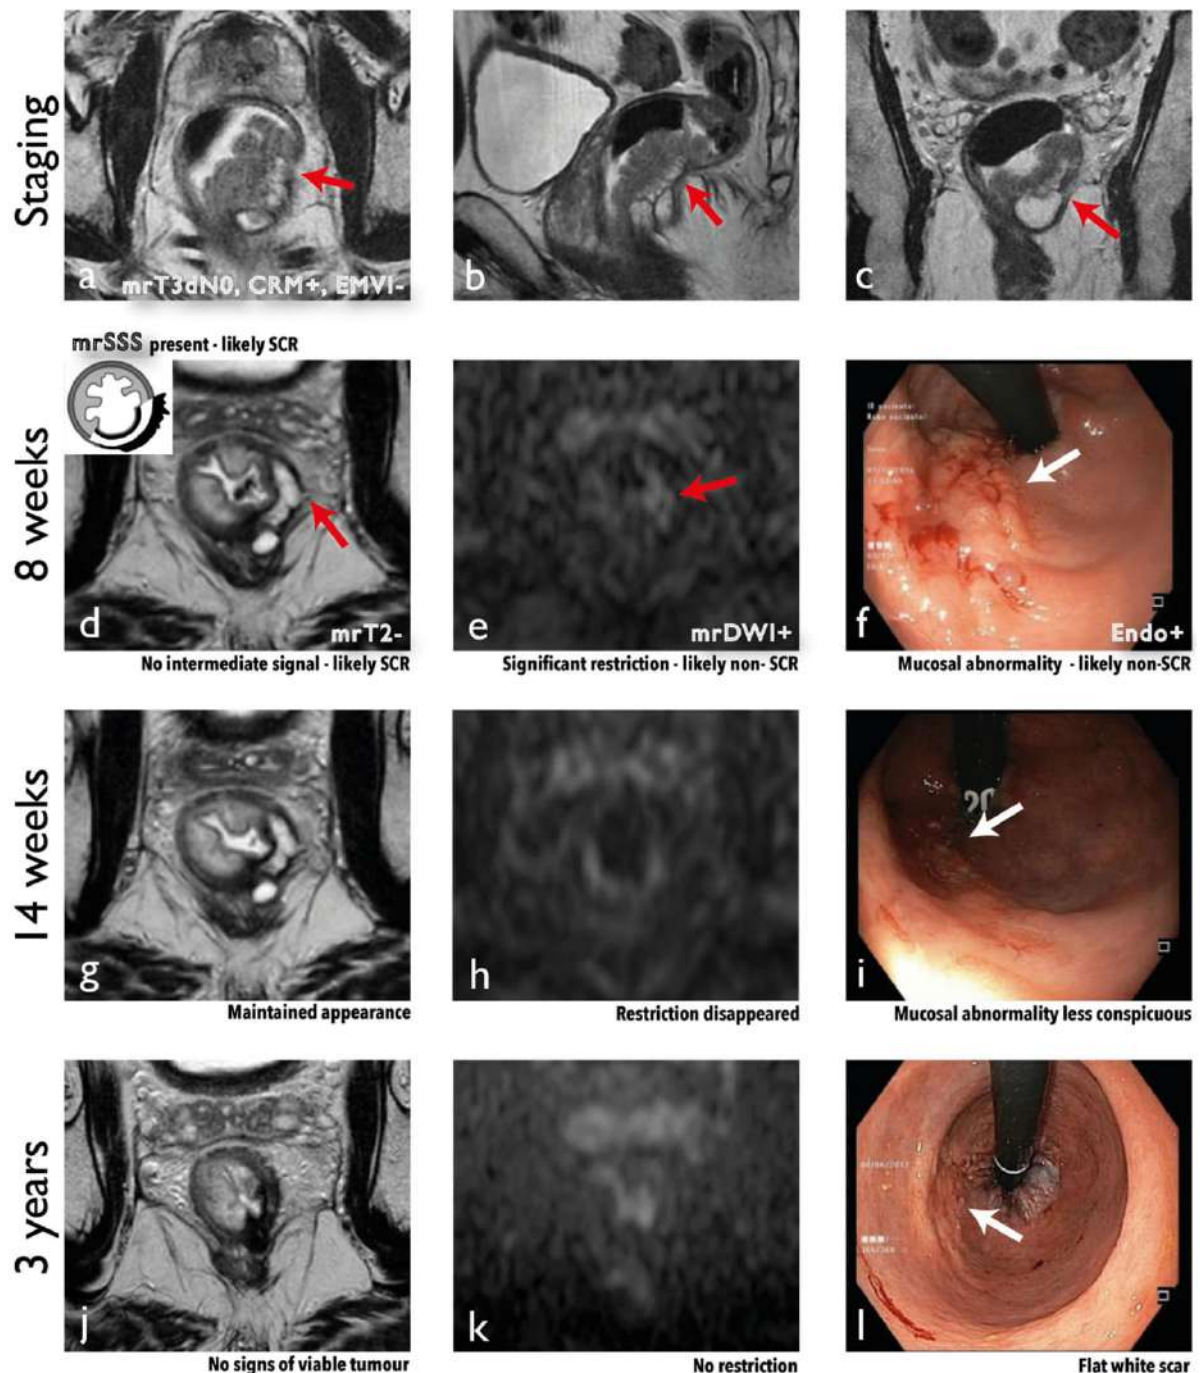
A 68-year-old male patient with a mucinous rectal cancer staged as mrT3d mrN0, mrEMVI- and mrCRM+ due to involvement of the sphincteric complex (arrows in a, b, and c). The patient underwent neoadjuvant chemoradiation. At first reassessment, 8 weeks after the end of radiotherapy, response was considered mrT2- and mrSSS+ by both observers due to an absent intermediate signal intensity and a clear split scar sign (arrow in d), respectively. Some hyperintensity was still apparent within the scar on DWI and the patient was considered mrDWI+ (arrow in e). Adenomatous residual mucosal abnormality was apparent on endoscopy (endo+) (arrow in f). On the second follow-up, at 14 weeks, the appearance
